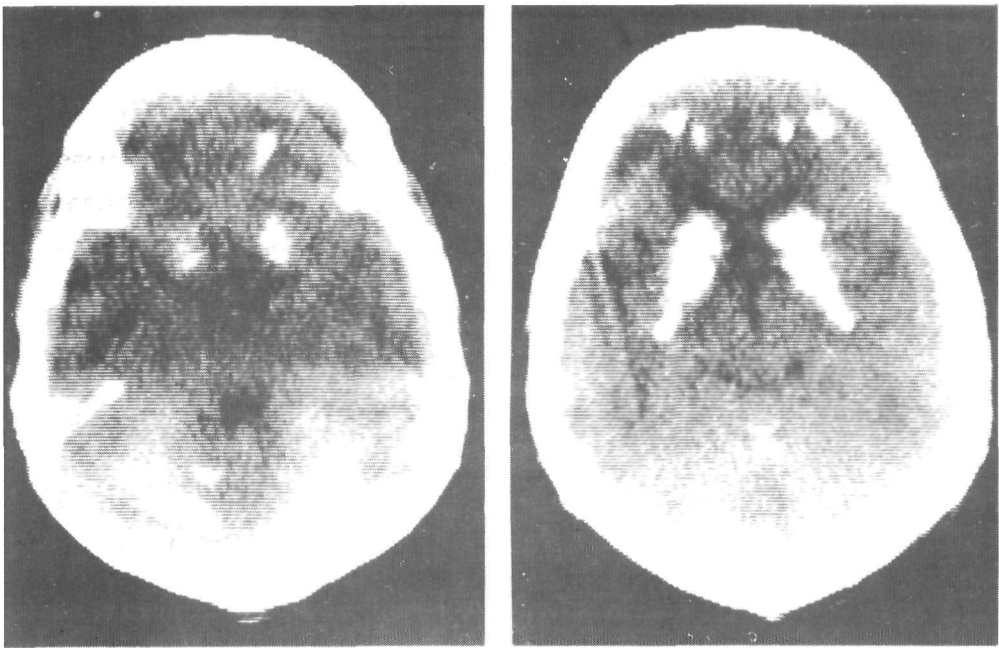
CT scan of case 1 showing calcification in the dentate nuclei, vermis superior, basal ganglia, and cerebral white matter
